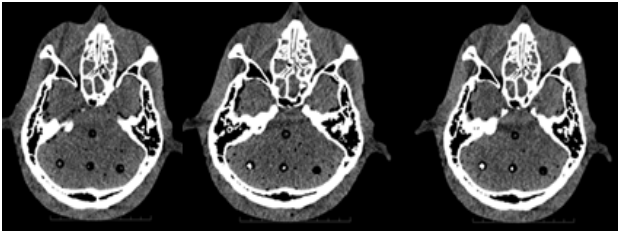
CT slices 92, 93 and 94 for OSL dosimetry
